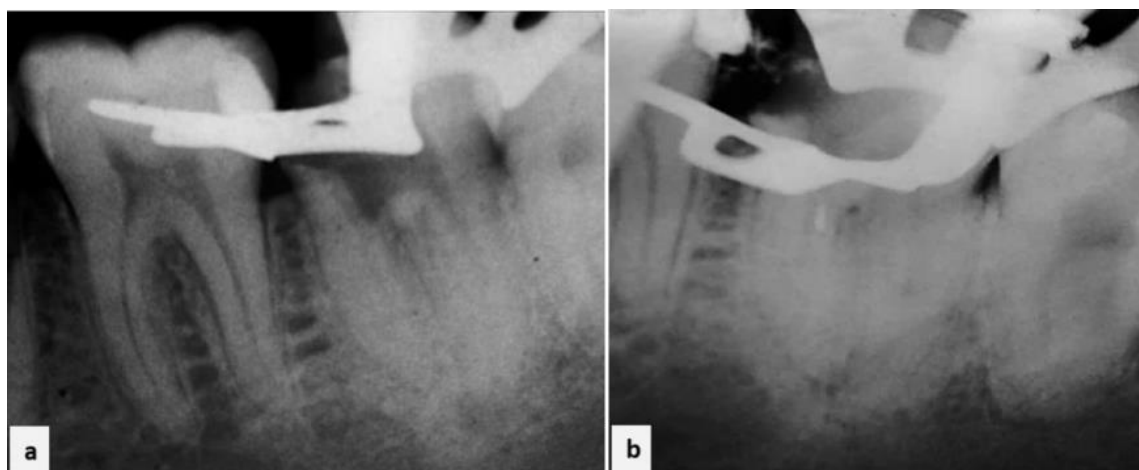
Pre-operative radiograph tooth #37.
